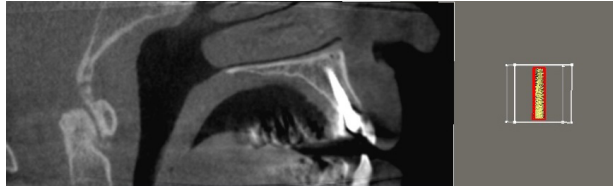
Manual alignment of the planning implant with the implant in the CBCT image.
